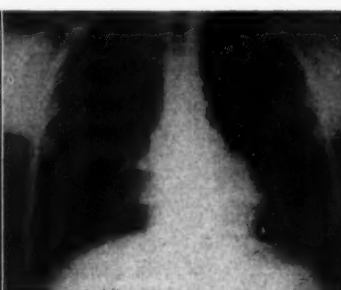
Case 10. Popcorn in right bronchus. X-ray plate negative. Pendulum motion at fluoroscopy. Inspiration.
